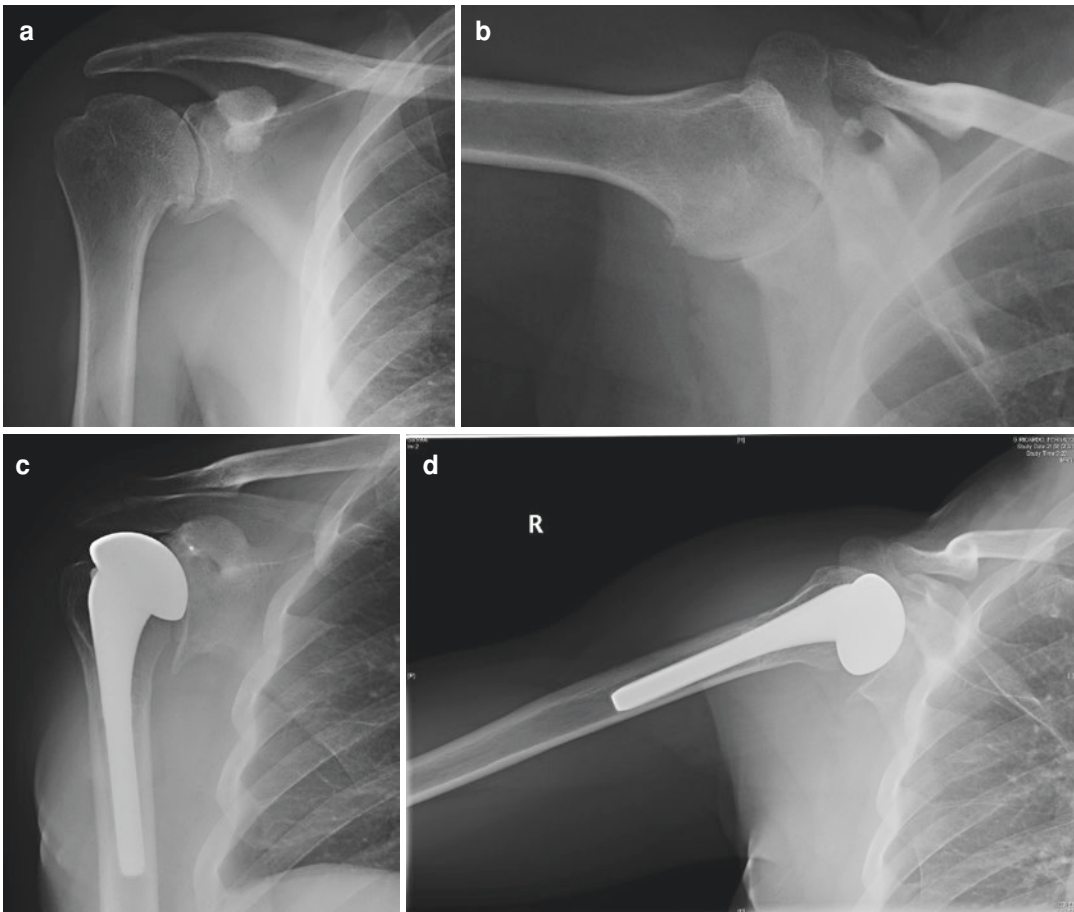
Preoperative X-ray images of a 48-year-old male with glenohumeral osteoarthritis in his right shoulder (a and b). A hemiarthroplasty was performed after extensive soft tissues release and glenoid microfractures in some of its surface. The inferior glenoid osteophyte was not adequately removed (c) and (d). Despite the X-ray's
